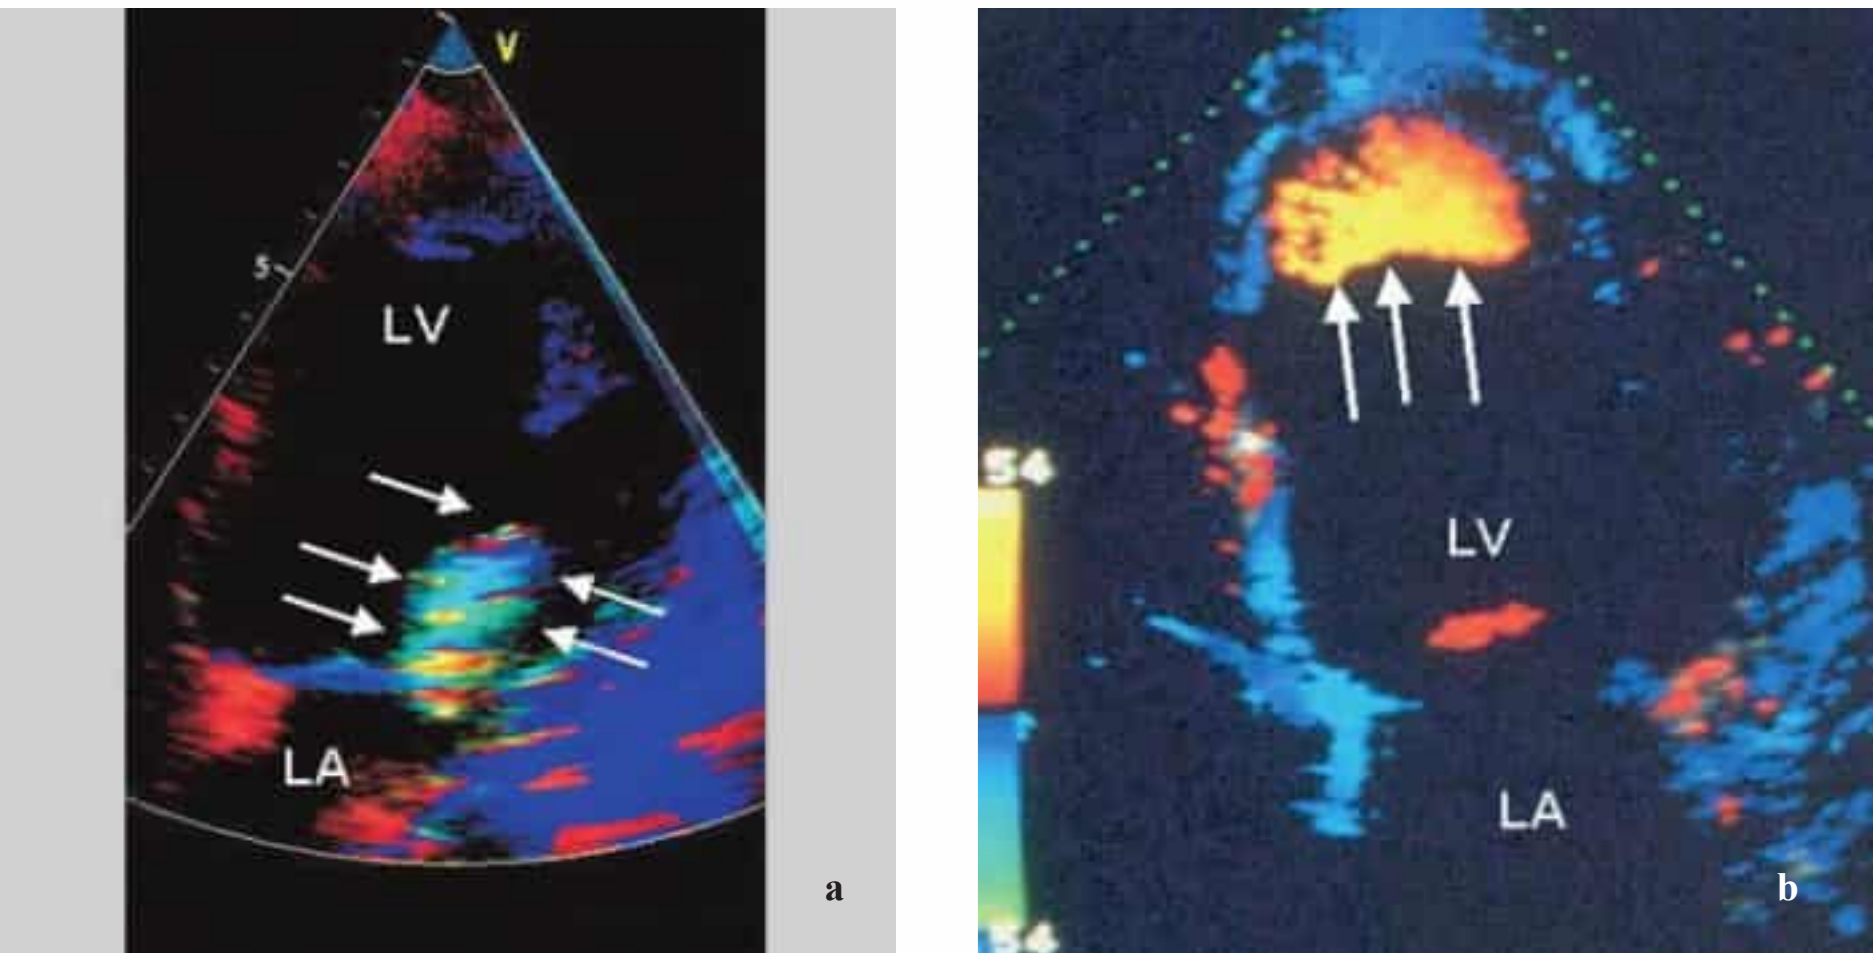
a, b Tissue Doppler echocardiography (TDE) of abnormal structures in the heart.
